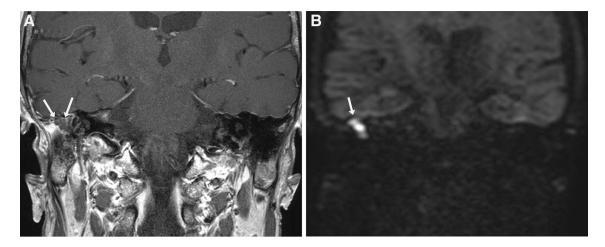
Cholesteatoma on MRI. a Coronal contrast-enhanced T1-weighted image shows non-enhancing material in the lateral epitympanum and upper mastoid region on the right (arrows). b This
